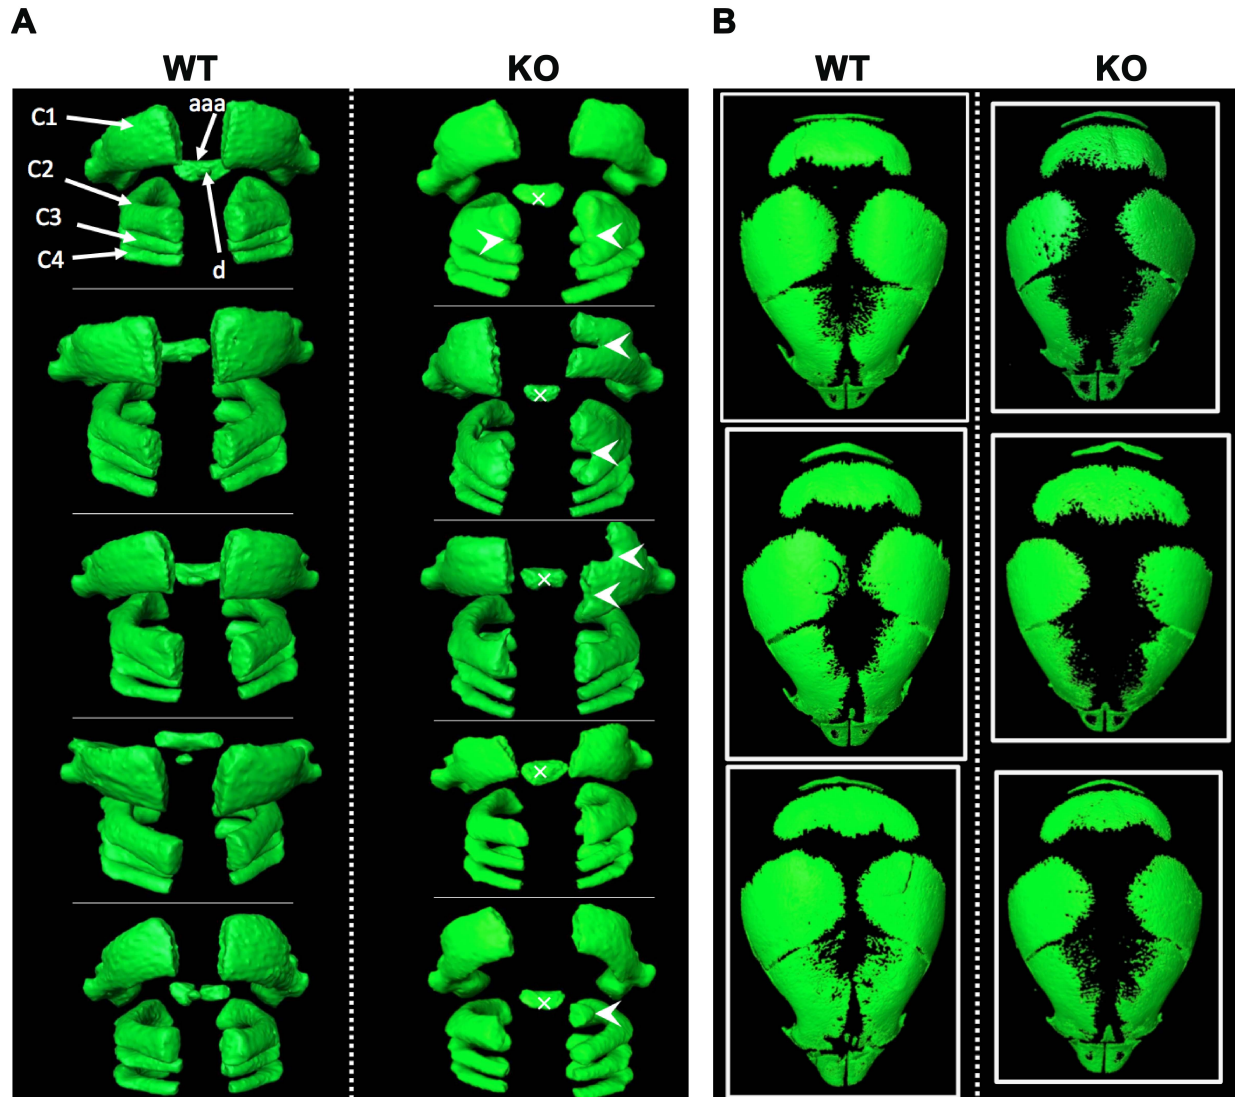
CT scan of vertebrae and skull
